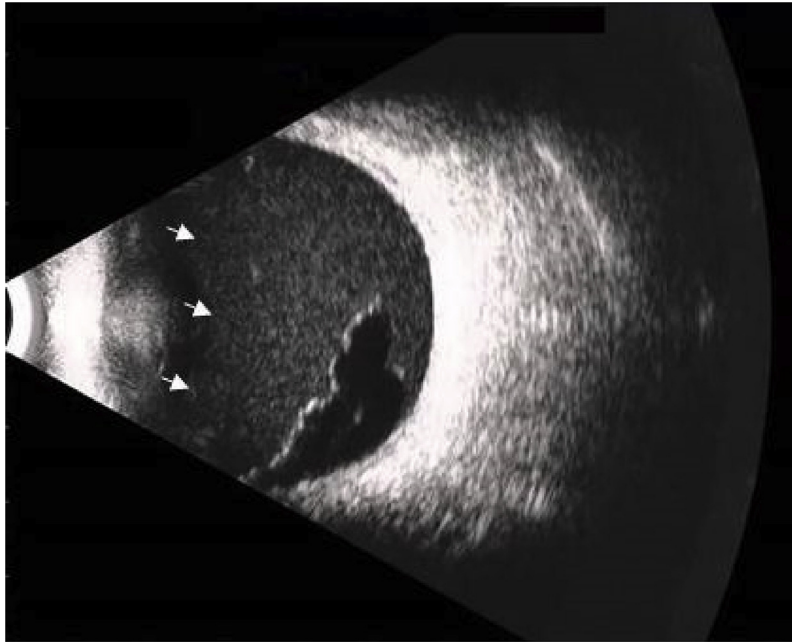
B-mode ophthalmic ultrasound scan of a 20 year old male, demonstrates the features of a fresh VH (arrows).
